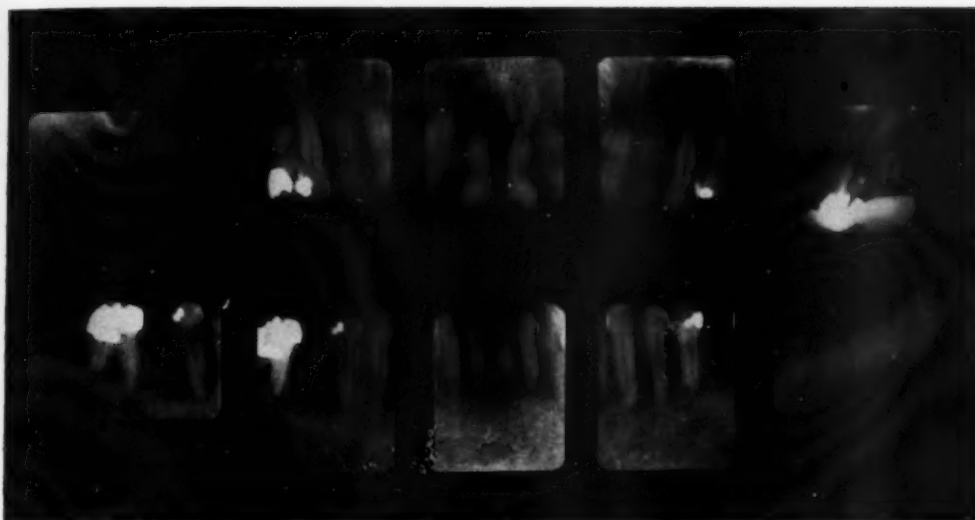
Cushing's syndrome. Dental roentgenograms showing uniform osteoporosis of both jaws. There is not the marked transformation of trabecular pattern seen in hyperparathyroidism. However, the lamina dura is only faintly discernible.
